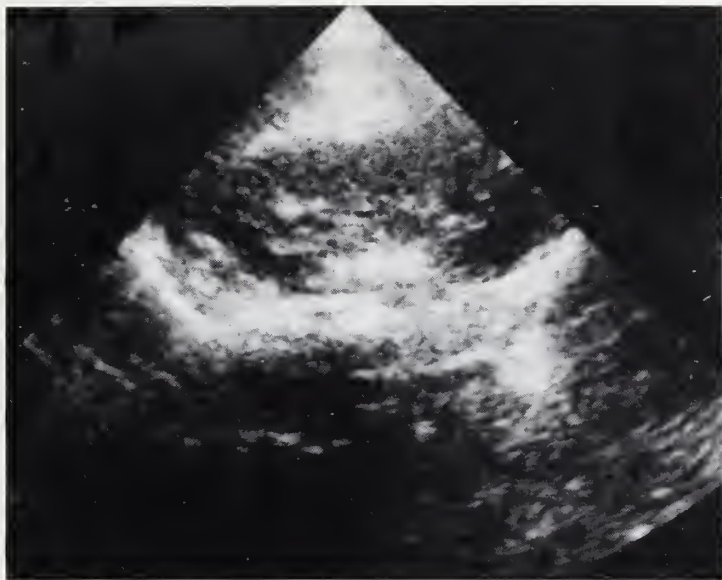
Sonogram at six weeks.
